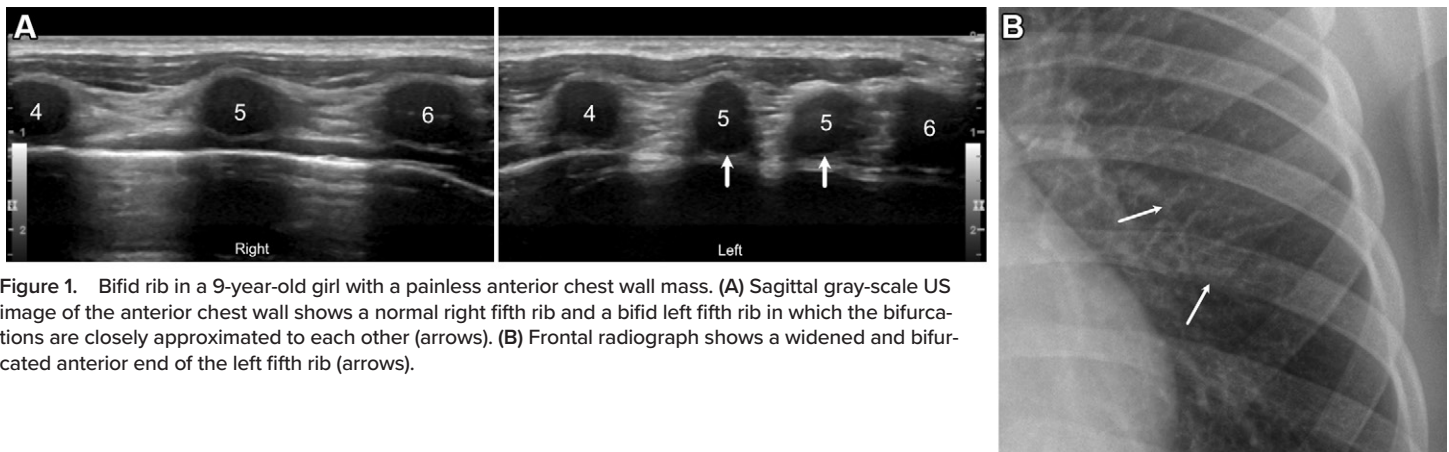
Bifid rib in a 9-year-old girl with a painless anterior chest wall mass. (A) Sagittal gray-scale US image of the anterior chest wall shows a normal right fifth rib and a bifid left fifth rib in which the bifurcations are closely approximated to each other (arrows). (B) Frontal radiograph shows a widened and bifurcated anterior end of the left fifth rib (arrows).
